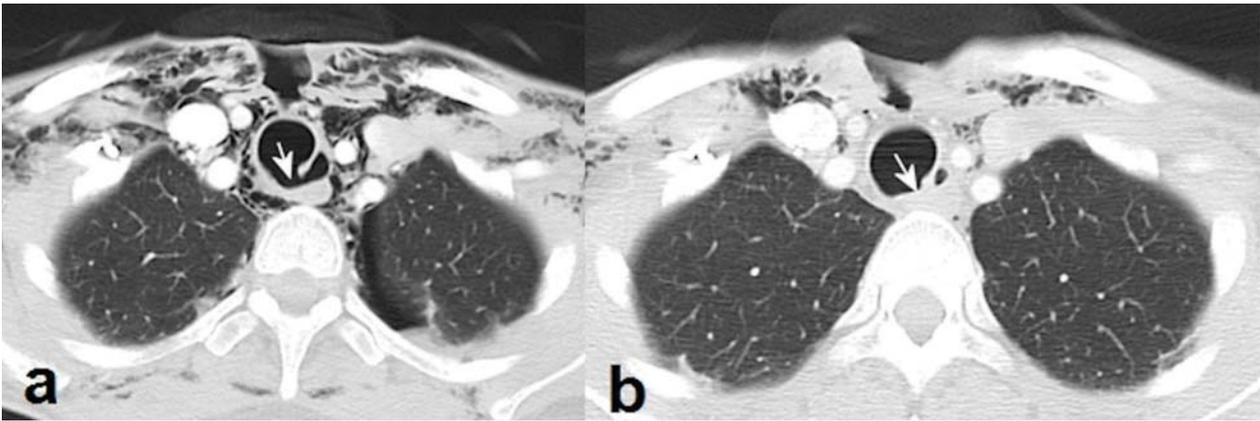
Thorax computed tomography images ; a) tracheal laceration (White arrow) and subcutaneous emphysema; b) After five days, healed tracheal laceration (White arrow).
